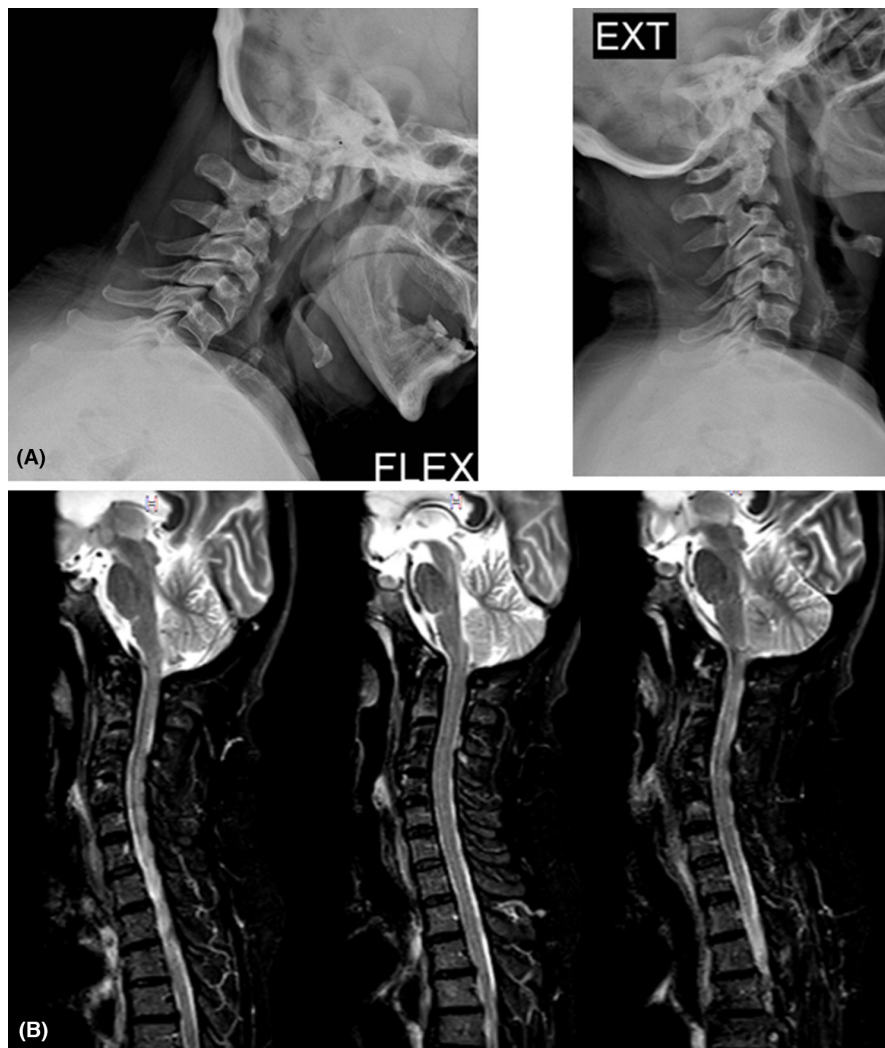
Improved cervical spondylitis and atlantoaxial instability in follow-up imaging. A. Dynamic cervical X-ray decreased C1-C2 subluxation. B. Cervical STIR MRI showing improved edema of cervical vertebral bodies
